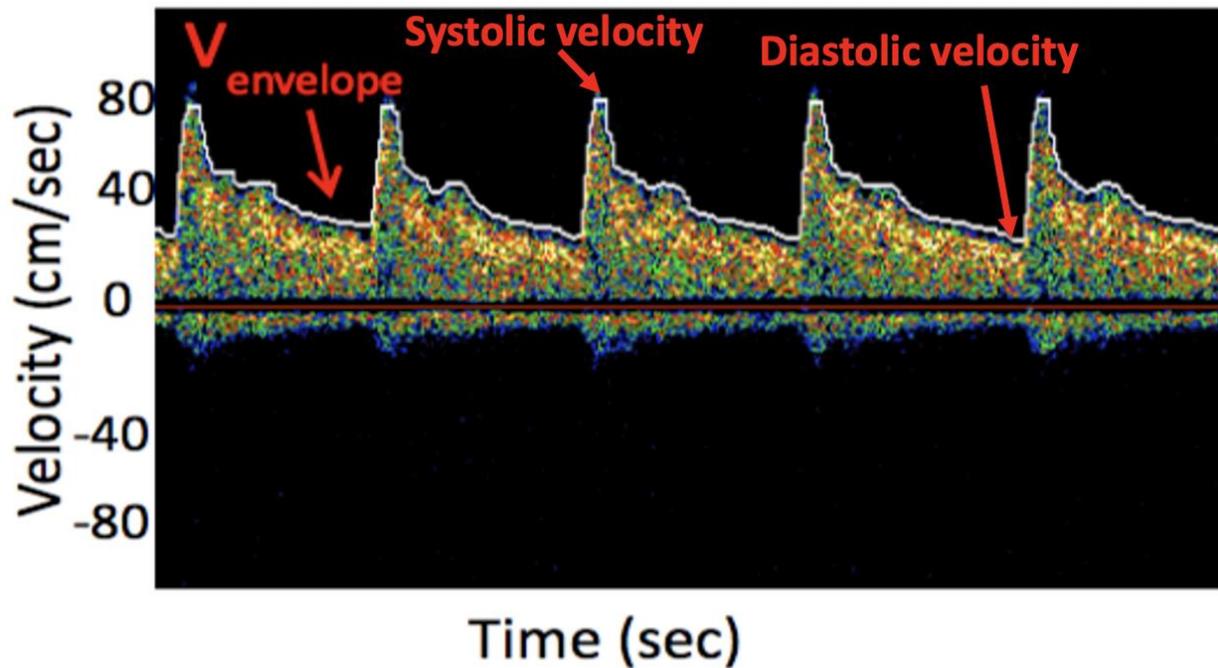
Example recording of the middle cerebral artery (MCA) using transcranial Doppler ultrasound (TCD).
